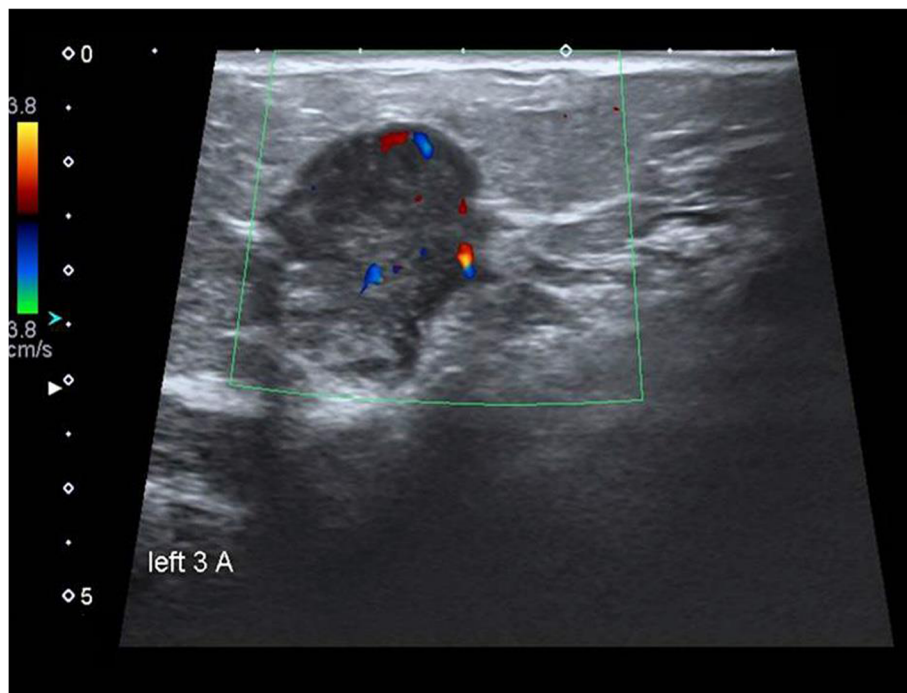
B mode ultrasound revealed hypoechoic irregular shaped mass with speculated margin, antiparallel orientation, and no posterior features. On CCDI, it shows internal vascularity, assessed as BIRADS 5. Pathology: invasive ductal carcinoma (grade I). Biological markers: ER positive, PR positive, HER/neu-2 negative, and Ki67 negative
